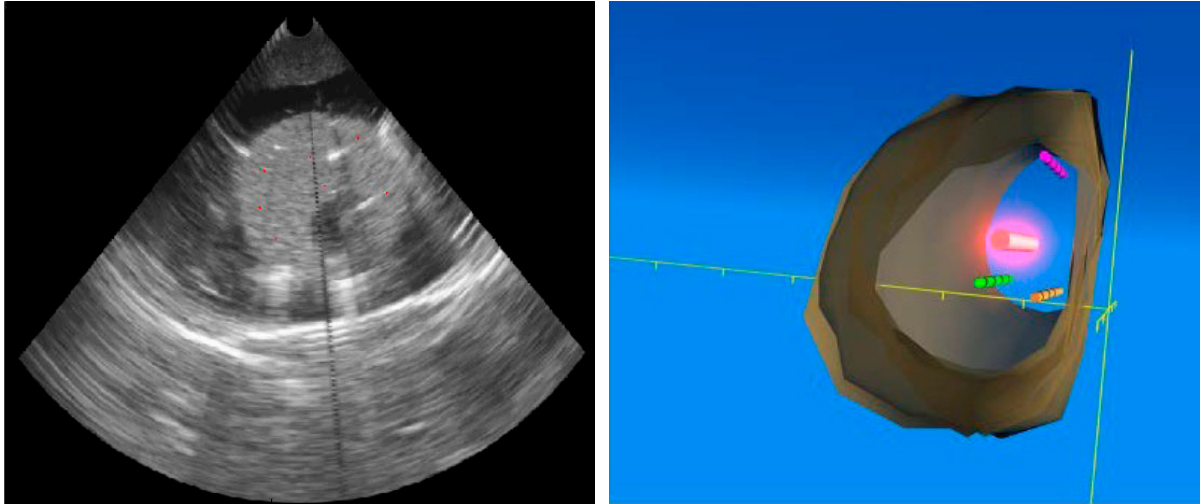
Left picture:* Transverse ultrasound view of the prostate model showing the location of the laser diffuser and multi-sensor probes for fluence rate monitoring (white marks). *Right picture:* Model of the prostate based on transverse ultrasound images. For clarity, the base and apex of the model were "cut". The glowing red rod represents the light diffuser, and the three other rods represent multi-sensor probes for fluence rate monitoring
